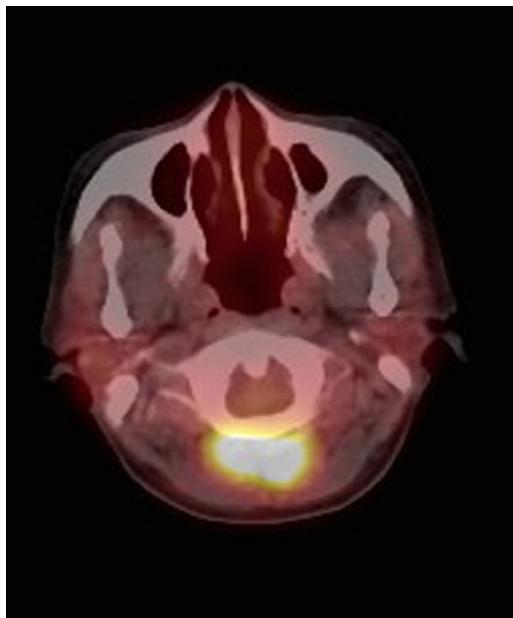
Positron emission tomography-computerized tomography (PET-CT) scan showed a soft tissue mass (SUV_{max}: 10.10) behind the posterior arch of C1.
